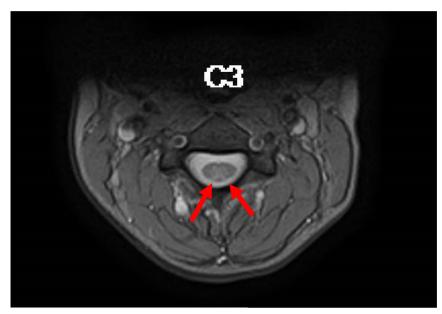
A. Axial T2W MRI at C3 vertebral level showing interval decrease in the T2W hyperintensity in the posterior columns of the cord.
